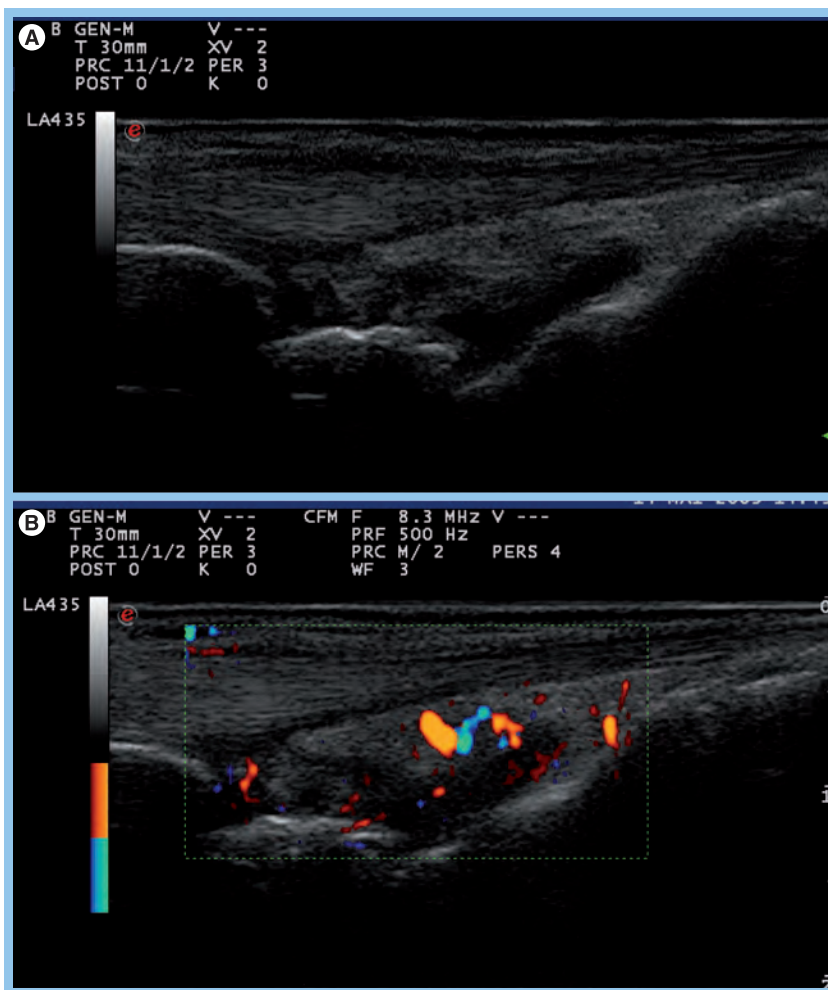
Dorsal longitudinal view of a wrist. (A) Grayscale and (B) Doppler sonographic image of wrist arthritis in a patient with rheumatoid arthritis.
